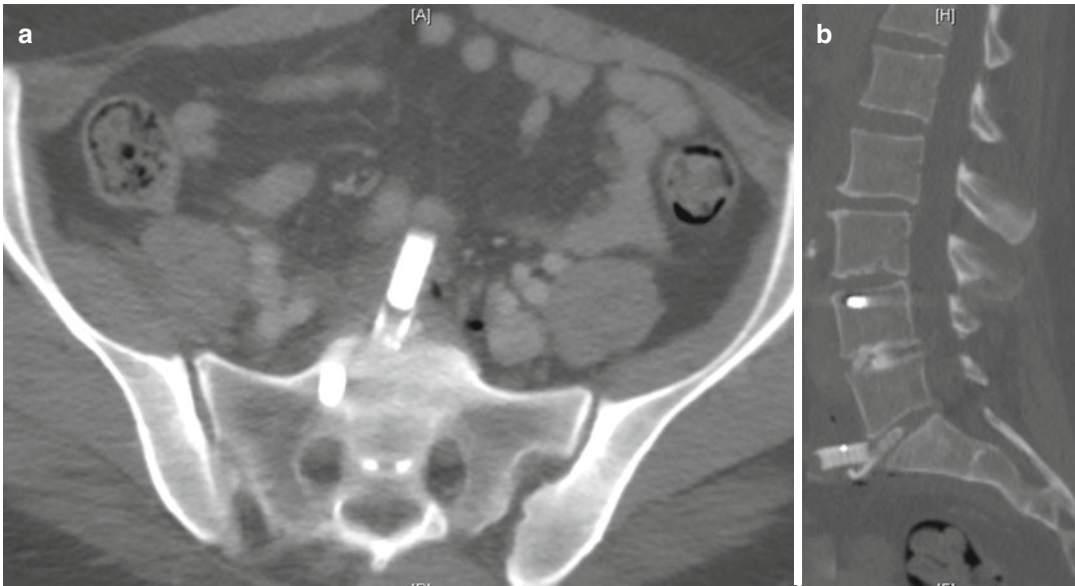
Axial image (a) and sagittal reconstruction (b) of a CT of the abdomen demonstrating violation of the anterior annulus and intra-abdominal intervertebral
